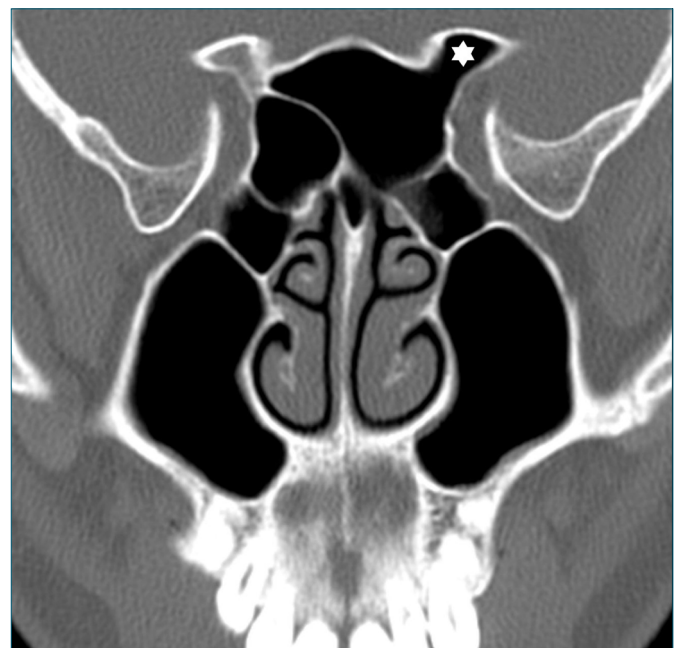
Coronal section CT image of a 35-year-old male patient, showing anterior clinoid process pneumatization (\*)
